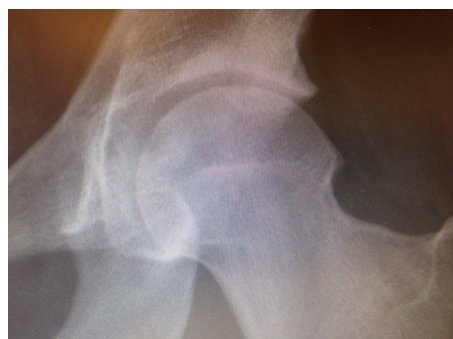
19-year old patient with osteoarthritis, in this image radiograph shown as slight lateral joint space narrowing, increased sclerosis and osteophyte formation. Arthroscopy showed advanced cartilage deterioration and thinning as well as typical osteophyte formation intra- and extraarticularly.
